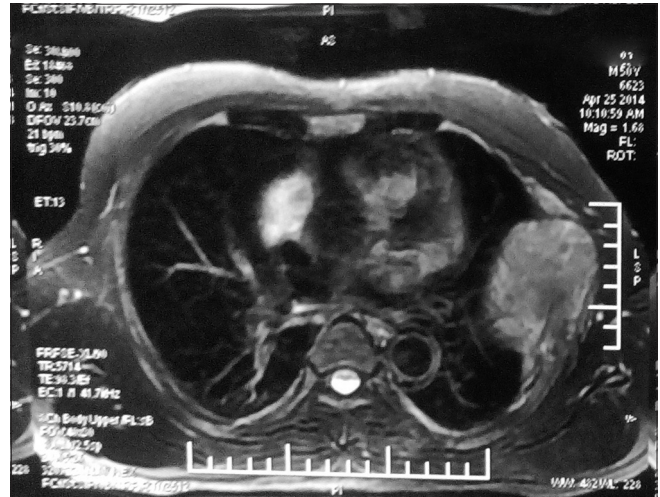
Magnetic resonance imaging thorax
